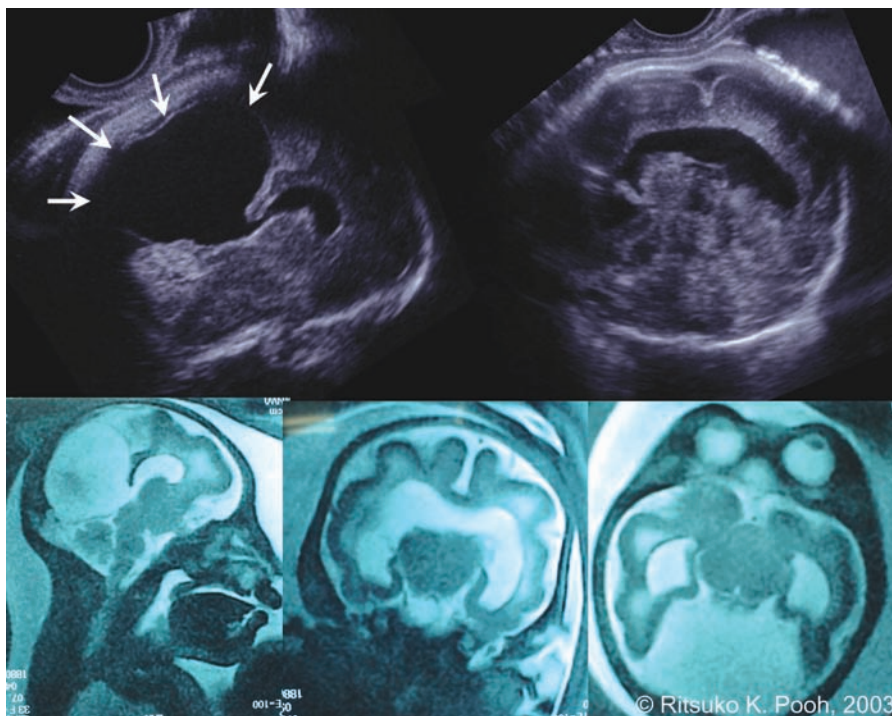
Semilobar holoprosencephaly at 33 weeks of gestation. Upper left shows dorsal sac (arrows) in the median section. Upper right demonstrates the fused ventricle. Lower figures are fetal MR images. Sagittal (left), coronal (middle), and axial (right) sections. A blind end of nasal cavity and hypotelorism are seen in the sagittal and axial MR images, respectively.
